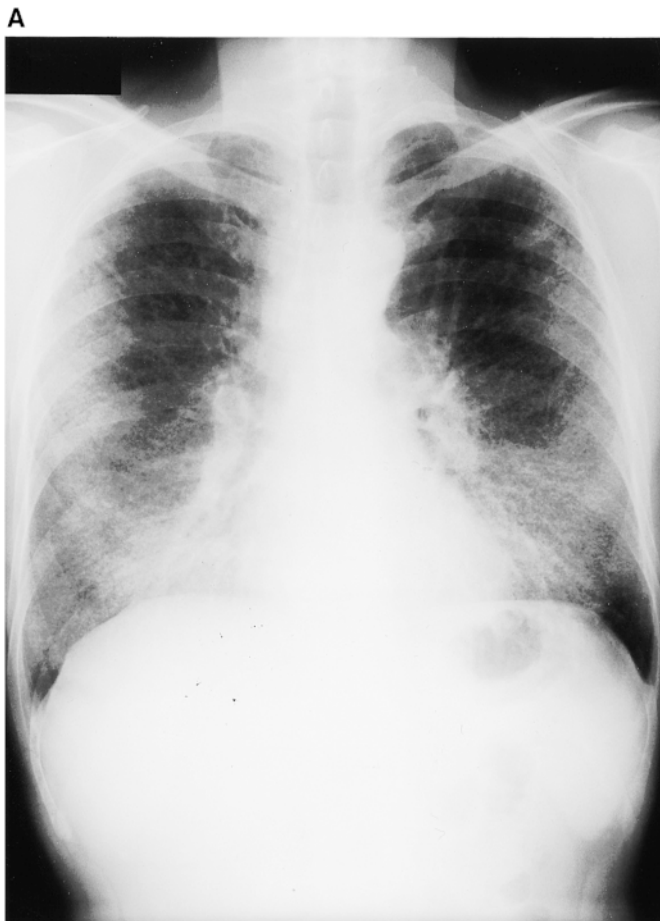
(A) Chest radiograph and (B) CT scan results for one of the cases of interstitial lung disease associated with nylon flock processing. The diffuse interstitial involvement is predominantly in a peripheral pattern.
